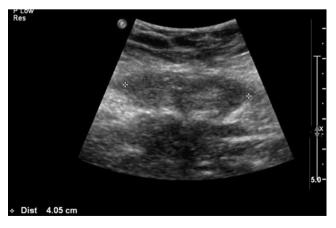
Ultrasound diagnosis of Caesarean scan endometrioma
